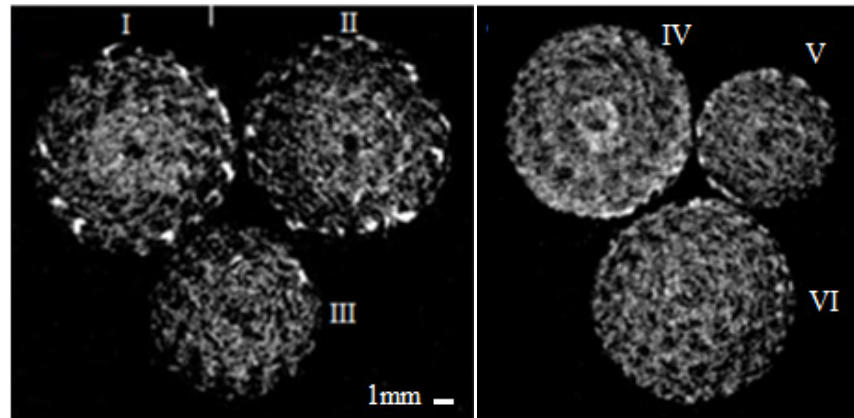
Two-dimensional CBCT slice images of SBF coated P(L/D)LA 96/4 scaffolds. Left image has a one day coated (I), a two days coated (II) and uncoated scaffold (III). Right image has a 14 days coated (IV), five days coated (V) and six days coated (VI) scaffold.
